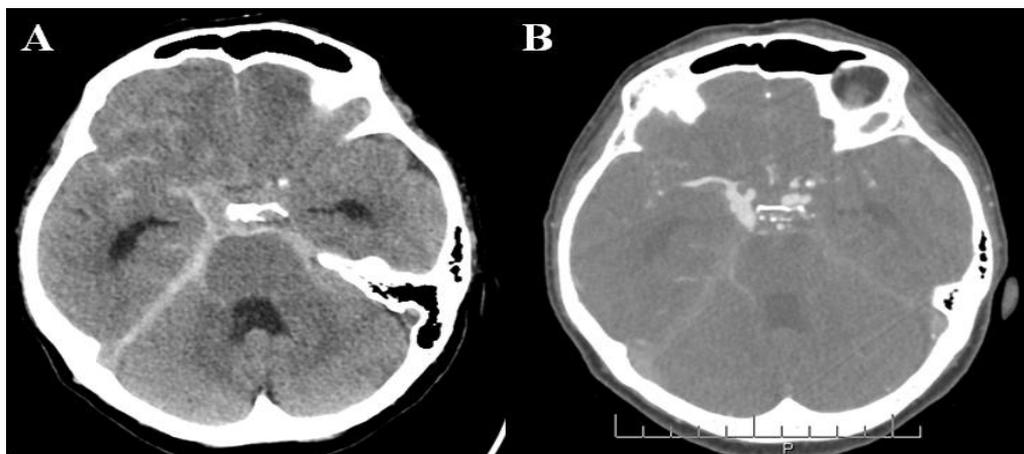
A. Computed tomography of the head: aneurysmal subarachnoid hemorrhage; B. CTA: vascular dysplasia and right PCoA aneurysm.
